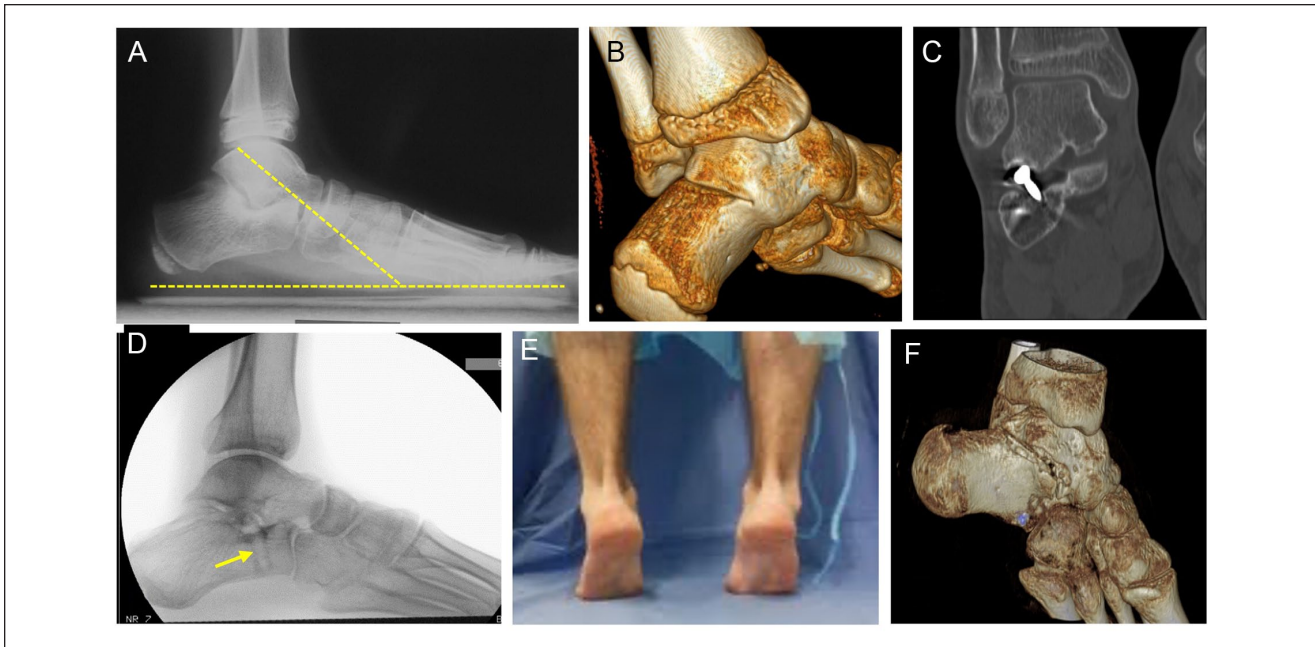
Thirteen-year-old boy affected by talocalcaneal coalition (TCC). (A) Preoperative weightbearing lateral view radiograph showing severe flatfoot deformity with the talar inclination angle (dashed lines) measuring 38 degrees. (B) 3D reconstruction showing a complete osseous coalition. (C) Computed tomography slice at follow-up after coalition resection and subtalar extraarticular screw arthroereisis (SESA) procedure showing screw position under the talus and resection site. (D) Radiograph at 6-year follow-up after coalition resection and SESA procedure in one step and after screw removal (yellow arrow shows screw mark). The correct anatomical talocalcaneal relationship is maintained. (E) Normal hind foot alignment and free subtalar motion in tiptoes standing. (F) 3D reconstruction at follow-up showing the coalition resection site.
